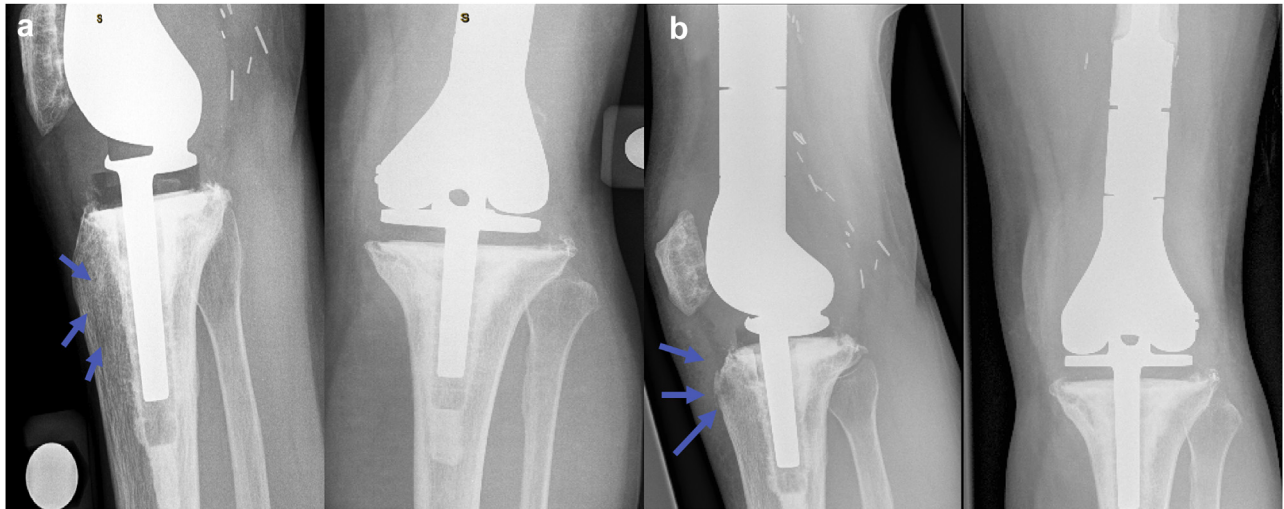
Plain radiographs showing polyethylene granuloma in patient A, left knee. (a) Initial presentation at 9 y postoperatively with asymptomatic benign appearing lesion posterior to the tibial tubercle (blue arrows). (b) Minimally displaced tibial tubercle fracture at 13 y postoperatively (blue arrows).
